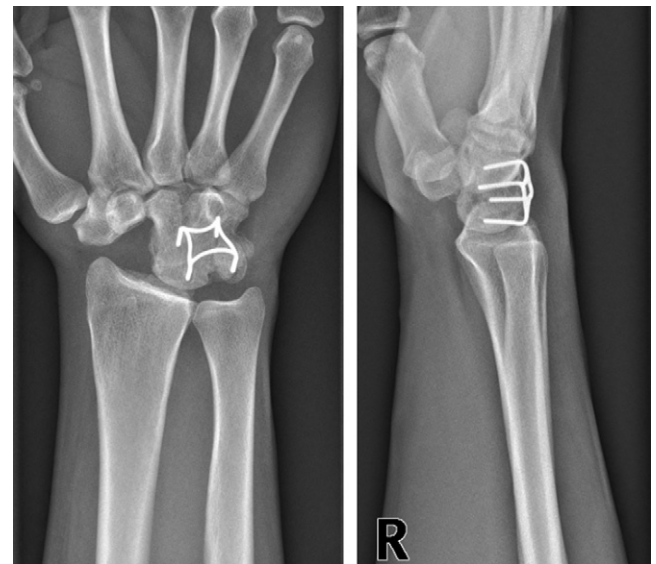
Postoperative radiograph: In this lateral view the staple appears proximally. A possible disadvantage of the technique is dorsal impingement of the staple against the radius when the wrist is in full extension.
